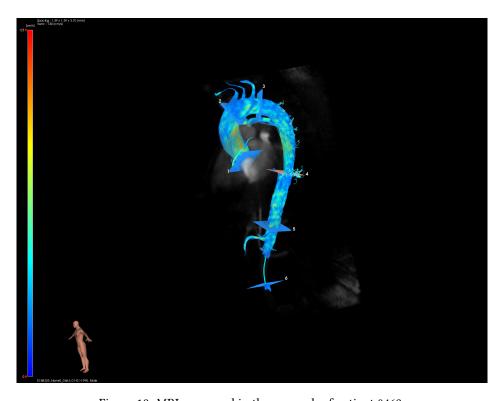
MRI scan used in the research of patient 0463.
